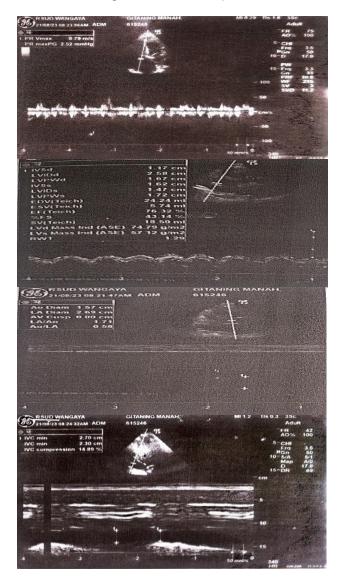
Echocardiography showed normal cardiac dimension with mild tricuspid regurgitation.
